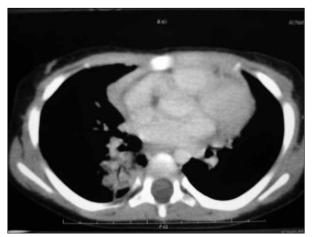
Computed tomography image of chest
